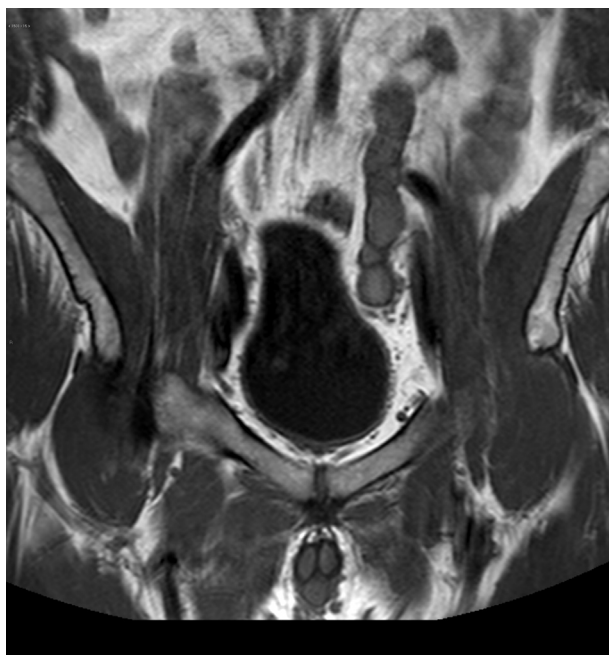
The coronal T1-weighted image showed a dilated and ectopic ureter draining into the left seminal vesicle with a length of 10 cm.
